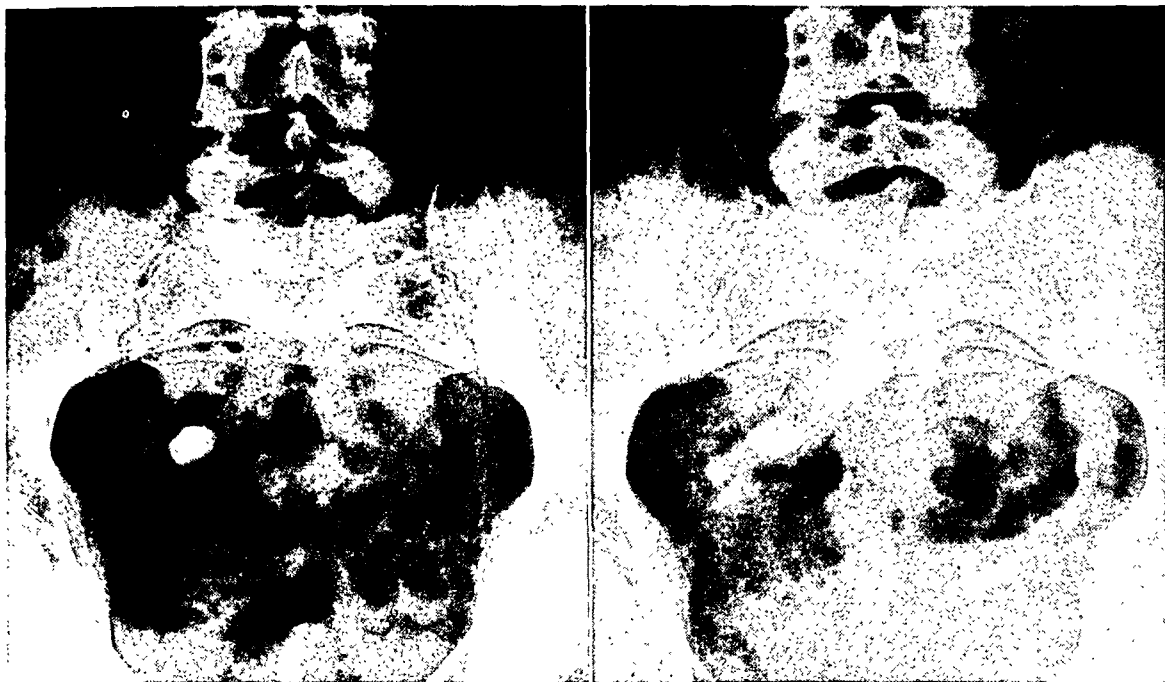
(left). Roentgenogram showing calculus in lower ureteral area.
